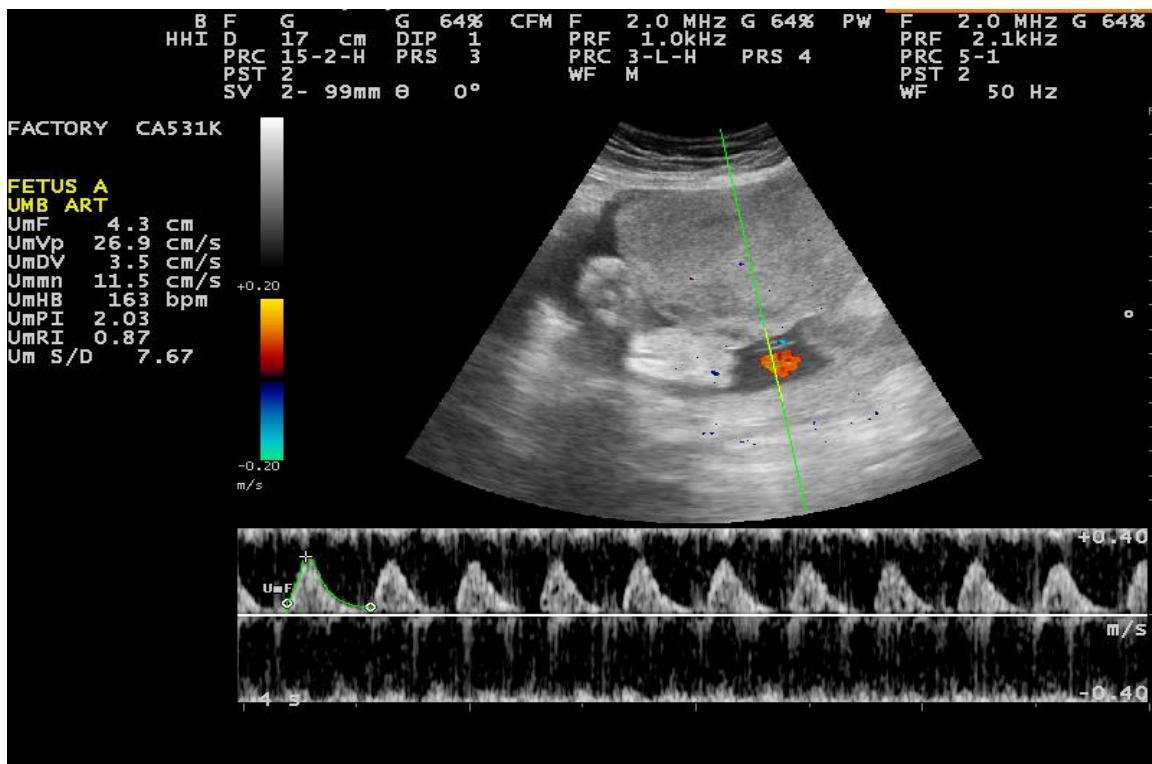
Color/Pulsed Doppler waveform of umbilical artery of perfuse twin
